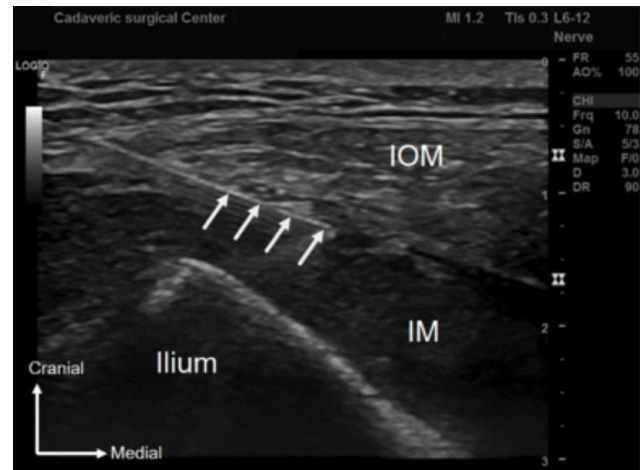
Ultrasound image of the suprainguinal fascia iliaca block. IOM: internal abdominal oblique muscle, IM: iliacus muscle, and white arrows: a needle underneath the fascia iliaca
